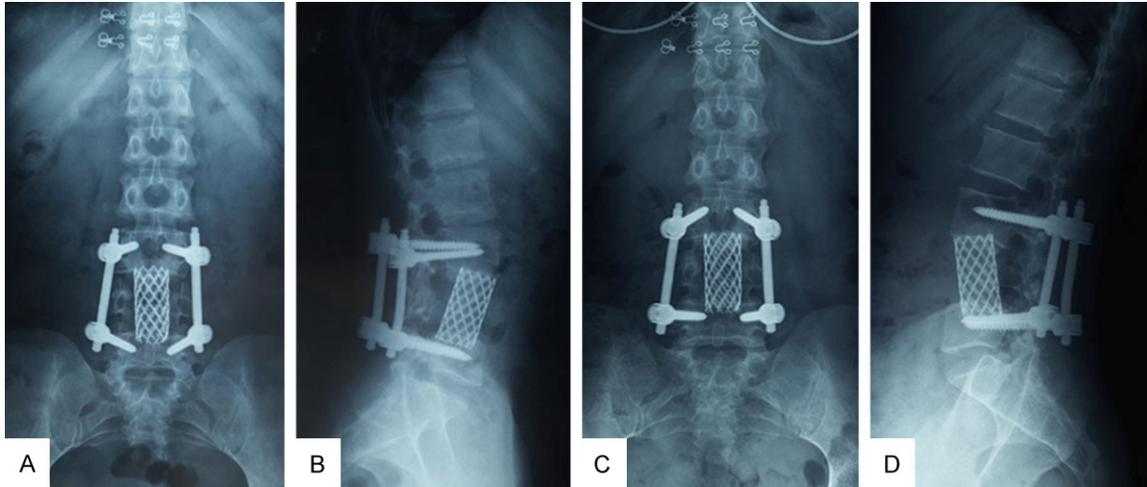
At her first-year (A, B) and second-year (C, D) follow-ups, the X-rays showed little cage subsidence.
